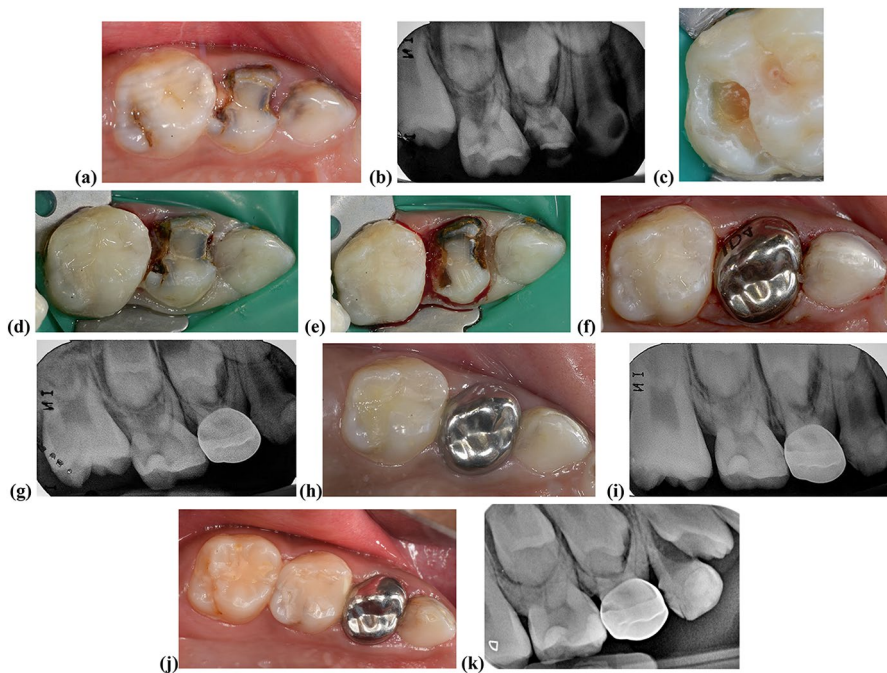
Clinical procedure of selective removal of carious tissue to soft dentine in primary teeth. a Preoperative view showing multisurface carious lesions in teeth 53, 54, and 55. b Radiograph showing deep carious lesions in teeth 54 and 55 involving the inner third of dentine without signs of pulp pathology and moderately deep lesion in tooth 53. c Selective removal of carious tissue, in tooth 55, to soft dentine on the floor of the lesion and to hard dentine in the periphery. d Restoration of teeth 53 and 55 with RMGIC. e Selective carious tissue removal to soft dentine in tooth 54. Tooth prepared to receive a PMC f PMC placed on tooth 54. g Postoperative radiograph. h Follow-up clinical view showing stable restorations and soft tissue healing. i Two-year follow-up radiograph showing stable restorations and increase in zone of remineralization below restoration in tooth 55. j Three-year follow up—stable restorations, healthy gingival tissue and fully erupted first permanent molar seen k Three-year follow-up radiograph demonstrates success of the treatment technique. Note the increase in the remineralized zone separating the deep restoration from the pulp in tooth 55
